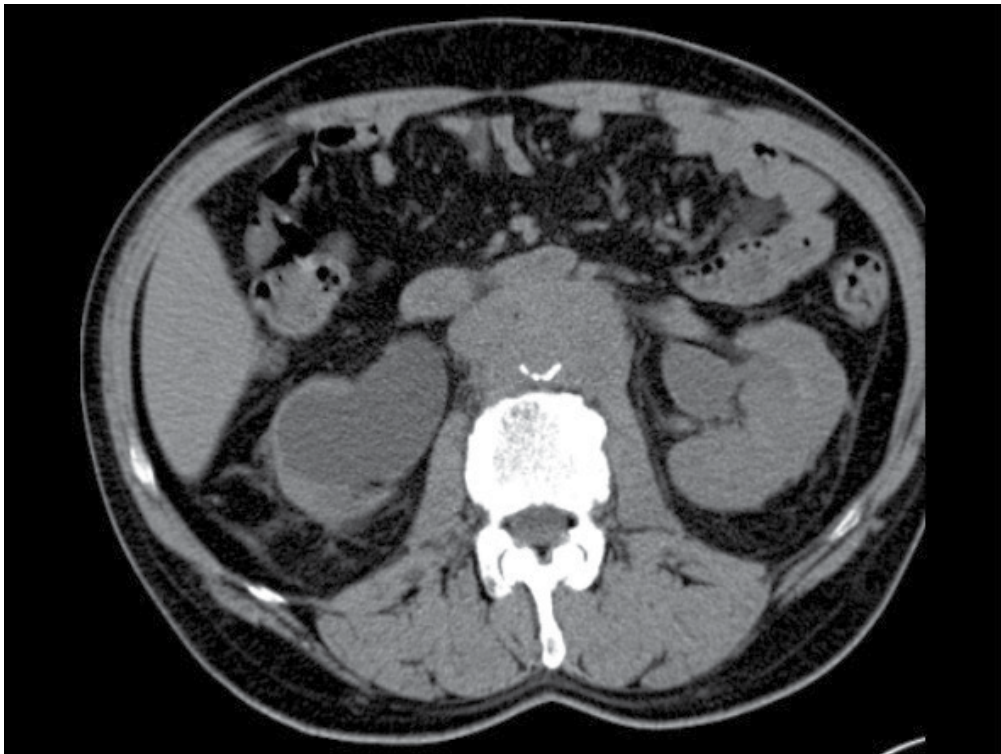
CT image of a patient with idiopathic RPF. Bilateral hydronephrosis and retroperitoneal infiltrates that envelop the aorta, iliac vessels, and ureters.
